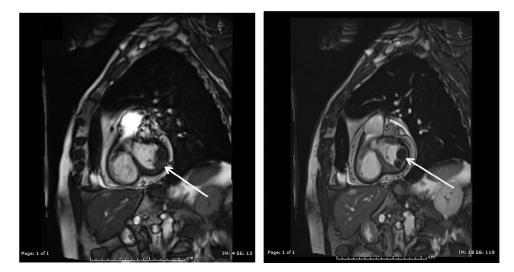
Cine magnetic resonance imaging along the short cardiac axis: 2 contiguous hypointense lesions (arrows).
